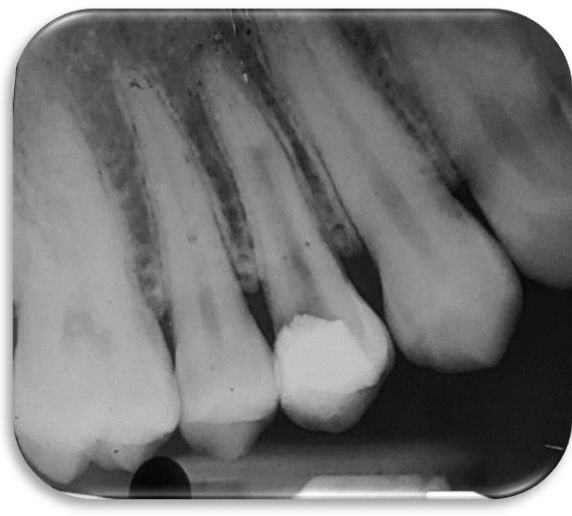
Check radiograph after instrument
